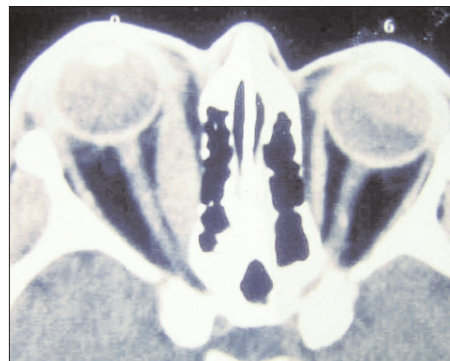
a- 60 years old female patient, unilateral thyroid ophthalmopathy, diplopia is present, pre-operative appearance. b- Orbital CT Scan; diffuse infiltration of the medial rectus muscle of the involved side. c- Late post-operative appearance, diplopia and hypoglobus persists.
